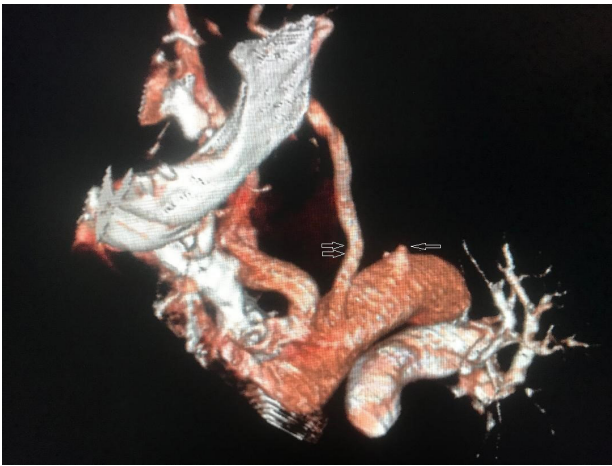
The single arrow on the CT angiogram demonstrates that the origin of the left subclavian artery is cut off. The origin of the left carotid artery is indicated with double arrows
